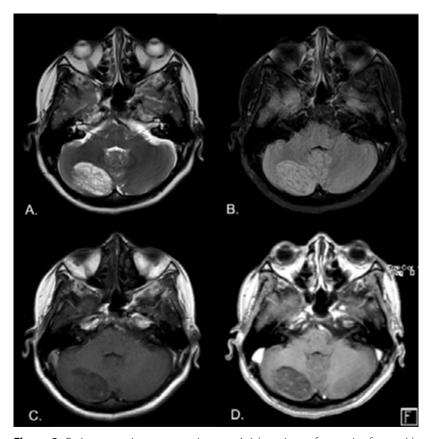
Brain magnetic resonance images. Axial sections of posterior fossa with T2-weighted sequences (A), FLAIR (B) T1 in single phase (C) and T1 postcontrast. Well-defined intraaxial lesion in the right cerebellar hemisphere. The lesion is mainly hyperintense on T2-weighted and FLAIR sequences (A and B), with a striated appearance, with alternating hyperintense and hypointense bands in relation to the adjacent gray matter. On T1-weighted images (C) it presents hypointense to isointense striations in the gray matter. After intravenous contrast administration (D), there is a slight peripheral enhancement and punctate areas of intratumoral enhancement. There is no evidence of vasogenic edema or local mass effect associated with the lesion
